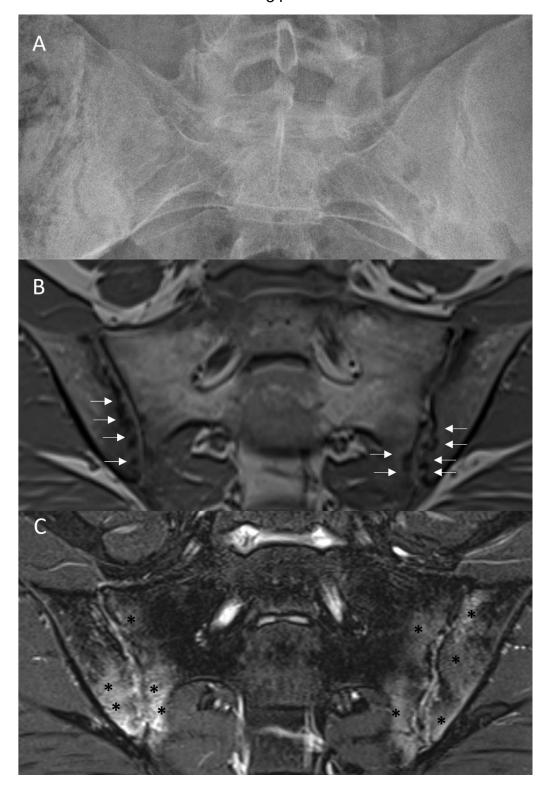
Psoriatic Arthritis in the Axial Skeleton – Pre-Radiographic Stage
